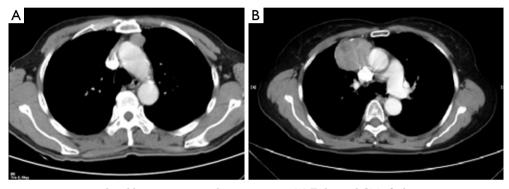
A tumor attenuation is considered homogeneous or heterogeneous. (A) Enhanced CT of a homogeneous tumor; (B) enhanced CT of a heterogeneous tumor.
